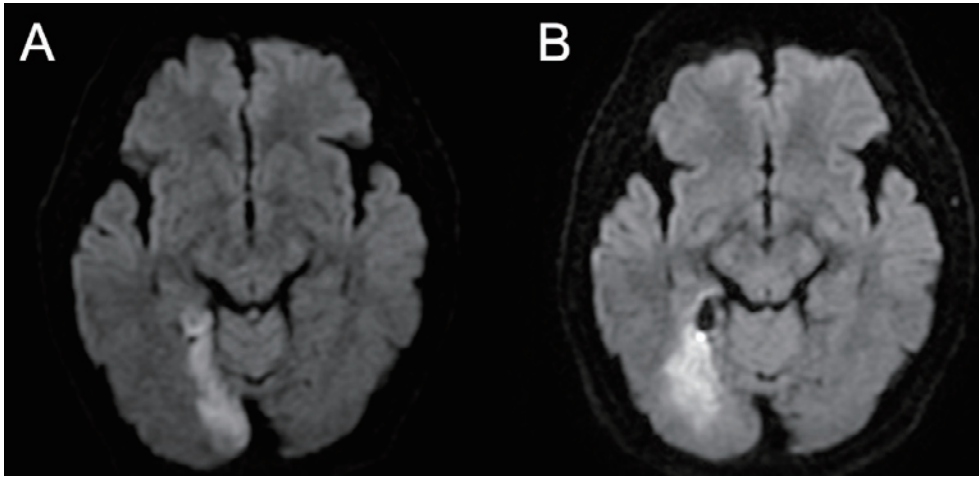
(A) Diffusion-weighted image (DWI) taken before treatment on day 1 and (B) DWI after treatment on day 12 shows enlargement of the right occipital lobe infarction in the tributary area of the right calcarine artery. The aneurysm already embolized with coils shows low signal intensity.
